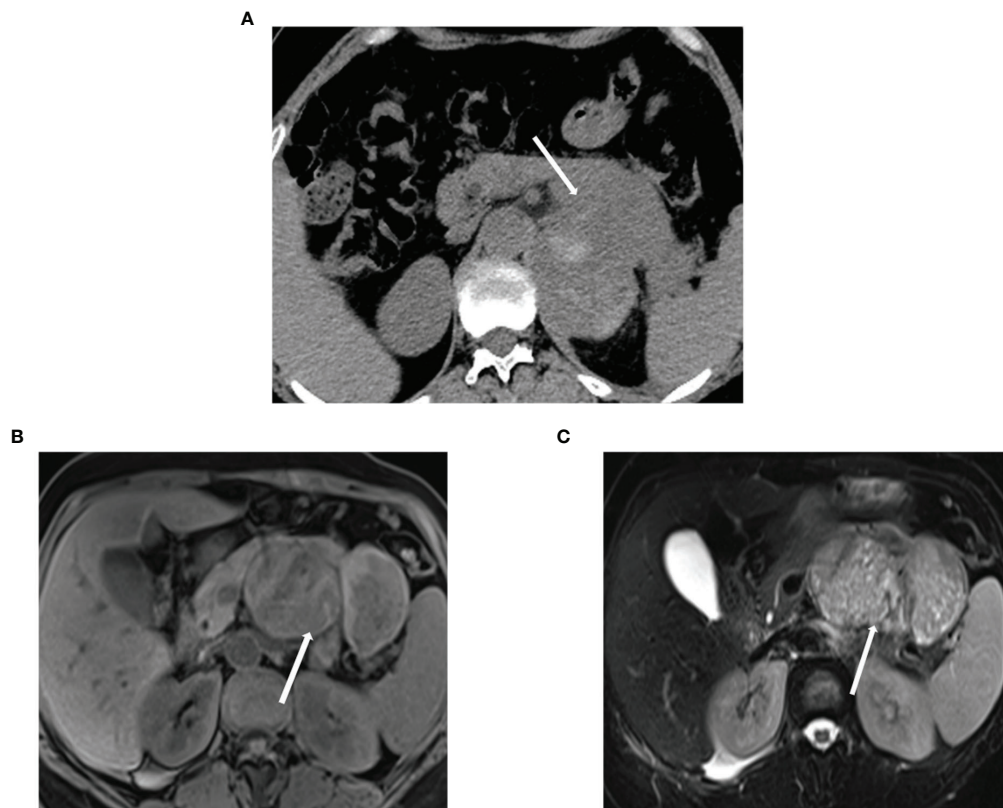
Calcification, bleeding, and necrosis (A) ACC in a 67-year-old woman. Unenhanced CT image reveals a pancreatic mass with irregular punctual calcifications (arrow). (B, C) T1-weighted and T2-weighted images reveal the tumor with the cystic necrosis (arrow). ACC, acinar cell carcinoma.
